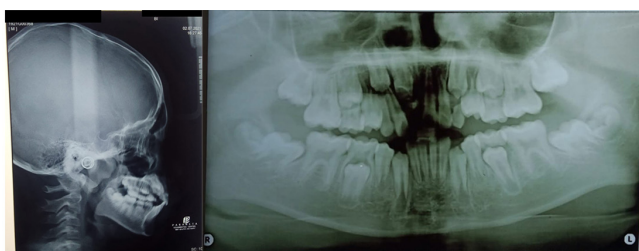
Pre treatment panoramic and cephalometry radiograph. The photo showed a radiopaque lesion in the region of the lump, surrounded by radiolucency in the anterior area of the anterior maxilla. Due to the lack of facility the quality of the radiograph panoramic photo was not quite good.
